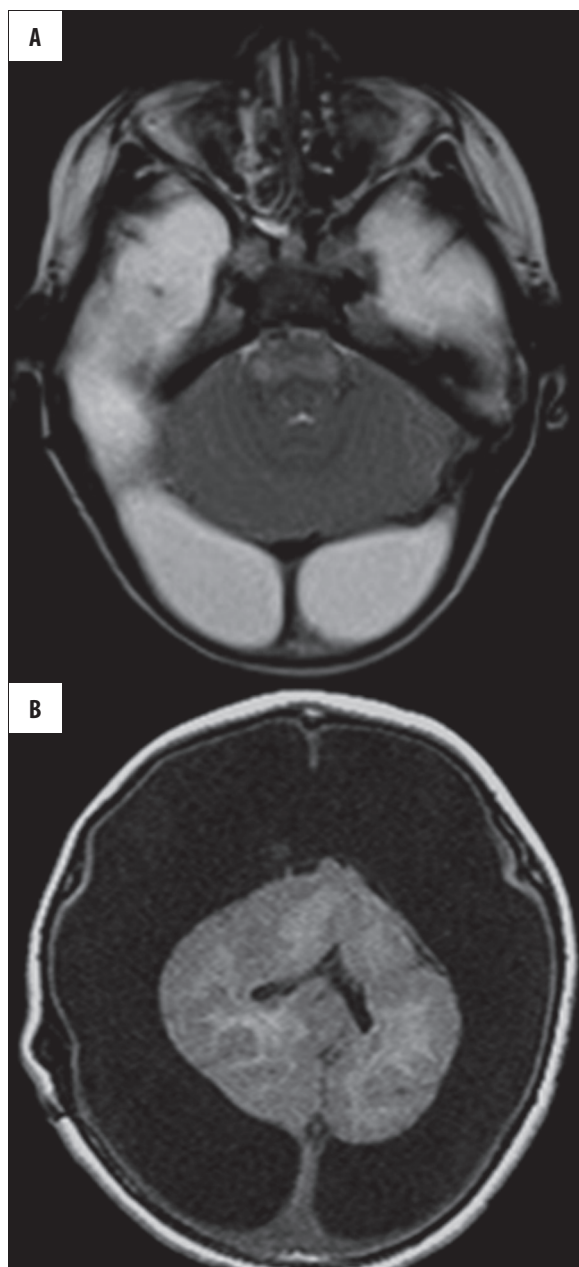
Case 5. Total RES with aprosencephaly/atelencephaly, abnormal signal intensity of the pons and wide extraaxial fluid collections. (A) FSE/T2-weighted image, axial plane; (B) SE/T1-weighted image, axial plane.
